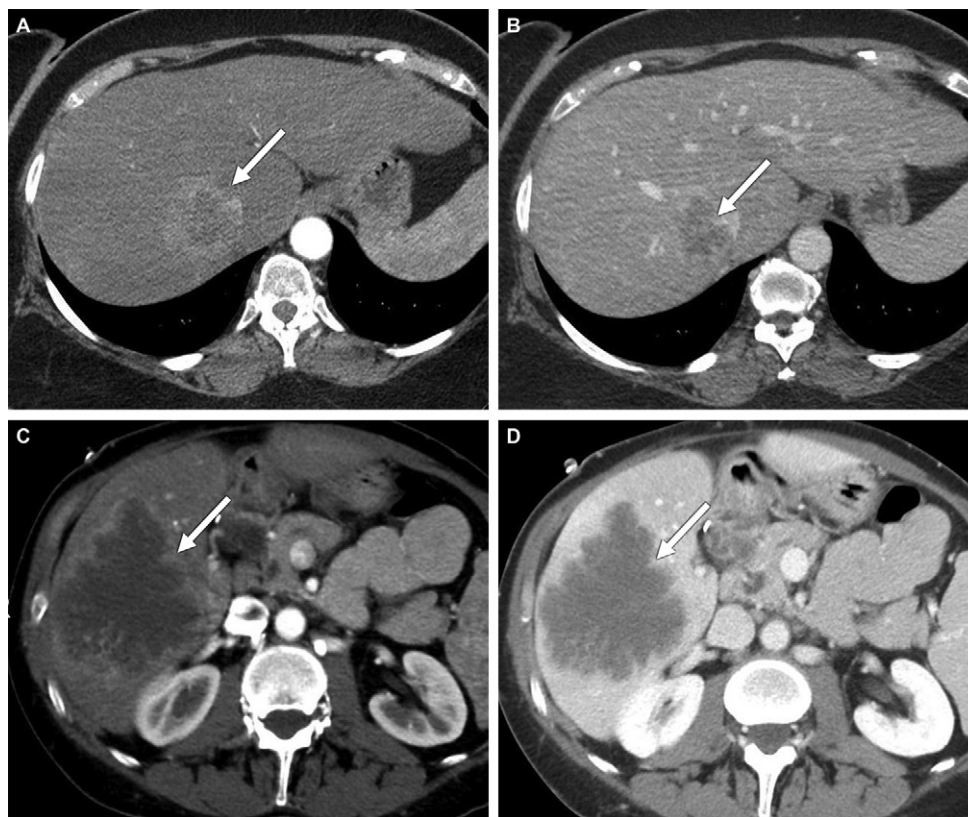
CT images show examples of observations that meet criteria for Liver Imaging Reporting and Data System (LI-RADS) category LR-M (probably or definitely malignant, not hepatocellular carcinoma [HCC] specific). Axial contrast-enhanced CT in (A) arterial phase and (B) portal venous phase in a 56-year-old woman with nonalcoholic steatohepatitis-induced cirrhosis demonstrates a 36-mm observation (arrow, B) with rim arterial phase hyperenhancement (arrow, A). Pathology revealed intrahepatic cholangiocarcinoma. Axial contrast-enhanced CT in (C) arterial phase and (D) portal venous phase in a 63-year-old man with hepatitis C virus cirrhosis demonstrates a 90-mm observation (arrow, D) with rim arterial phase hyperenhancement (arrow, C). Pathology revealed poorly differentiated HCC with p53 mutation.
